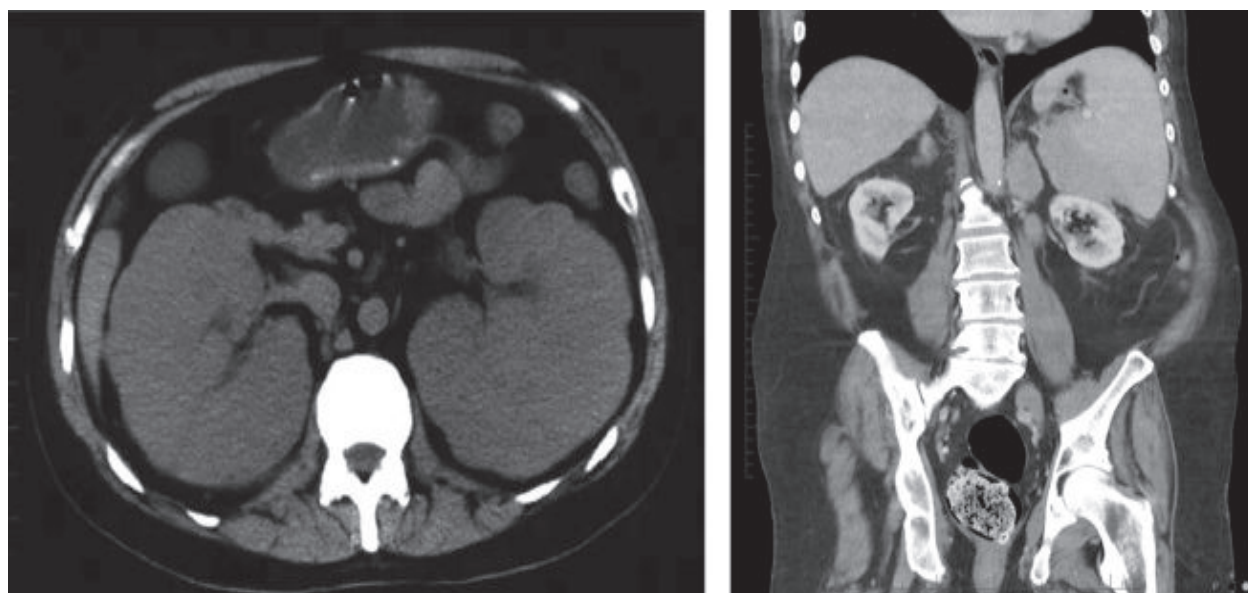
Non contrast CT Scan of whole abdomen showed bilateral enlarged kidneys.*
